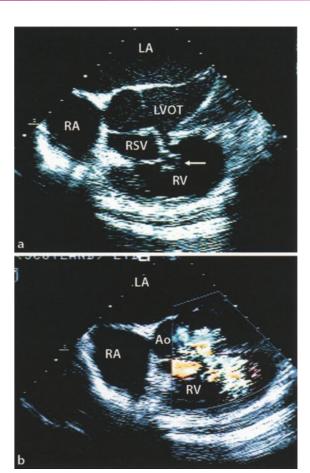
Aneurysm of Valsalva: a intraoperative transesophageal echocardiography of the same patient as in Fig. 2.10.1, showing the ruptured aneurysm of the right sinus of Valsalva (arrow) protruding into the right ventricle through a large ventricular septal defect (*LA* left atrium, *LVOT* left ventricular outflow tract, *RA* right atrium, *RSV* right sinus of Valsalva, *RV* right ventricle), b intraoperative transesophageal Doppler echocardiography of the same patient, showing the left-to-right shunt aorta-to-right ventricle from the ruptured aneurysm of the right sinus of Valsalva (*Ao* aorta)
